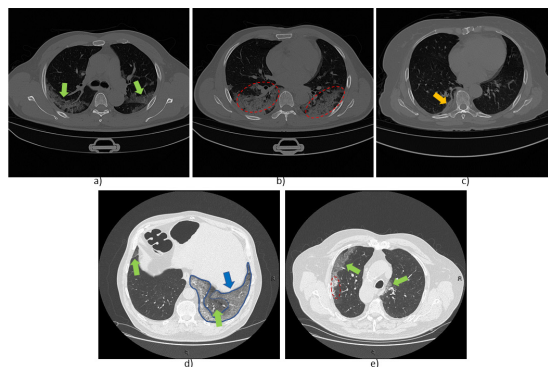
Images with different abnormal findings from CT scans of the database. GGO is indicated with green arrows in a), d) and e); consolidation is enclosed by segmented red ovals in b) and e); pleural effusion is indicated with yellow arrow in c); and crazy-paving pattern is enclosed by a blue line in d).
